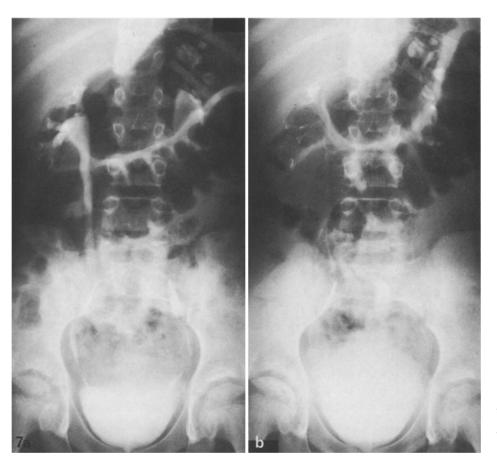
a and b. Under-estimation of bladder volume (,,supine radiographs"). a IVP after ureteral reimplants reveal slight fullness of ureters and right pelvicalyceal system, raising the possibility of mild UV obstruction. The bladder does not appear to be very full. Note that the upper margin of contrast material in the bladder is unsharp. b After several hundred cc's were voided, the collecting systems and ureters have drained, suggesting that the hold-up at the UV junction was due to the full bladder [4, 11]. However the bladder appears to be fuller! This is because there was a large volume of non-opaque urine in the dome of the bladder which was not readily apparent on film a
